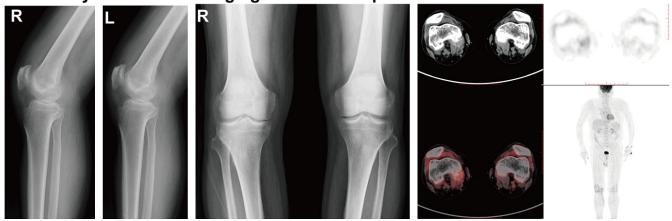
Legend of X-ray and PET/CT images of frail and non-frail patients. A. The left lateral, right lateral and orthopantomograms on X-ray and PET/CT images of a frail patient (male, 78 years old) defined as severe OA on X-ray images, with a high number of osteophyte formations, severe joint space narrowing, significant subchondral osteosclerosis and significant bony deformities of the knee joint. The ¹⁸F-FDG uptake was significantly increased (the SUVmax of the right keen was 4.4); B. The left lateral, right lateral and orthopantomograms on X-ray and PET/CT images of a non-frail patient (male, 74 years old) defined as mild OA, which showed bilateral tibial intercondylar eminences becoming pointed, few osteophytes at the femoral condylar edges and patellar edges, and bilateral tibiofemoral joint spaces becoming slightly narrower medially. The ¹⁸F-FDG uptake was mildly increased (the SUVmax of the right keen was 3.3).
